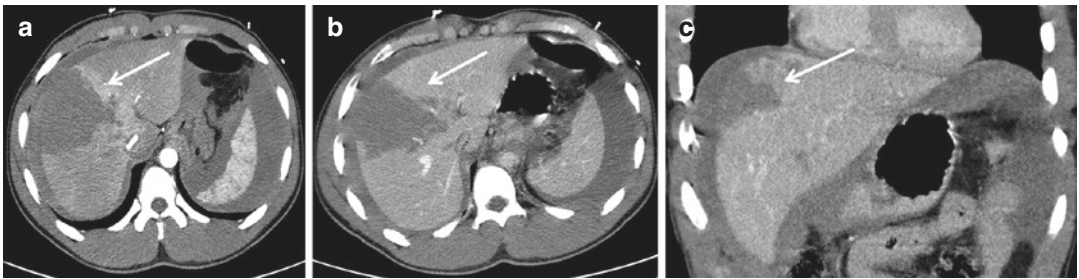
(a, b) Axial CT scan in arterial (a), venous phase (b) and (c) coronal reconstruction show the hepatic infarction as a hypodense triangular-shaped area (arrows).
